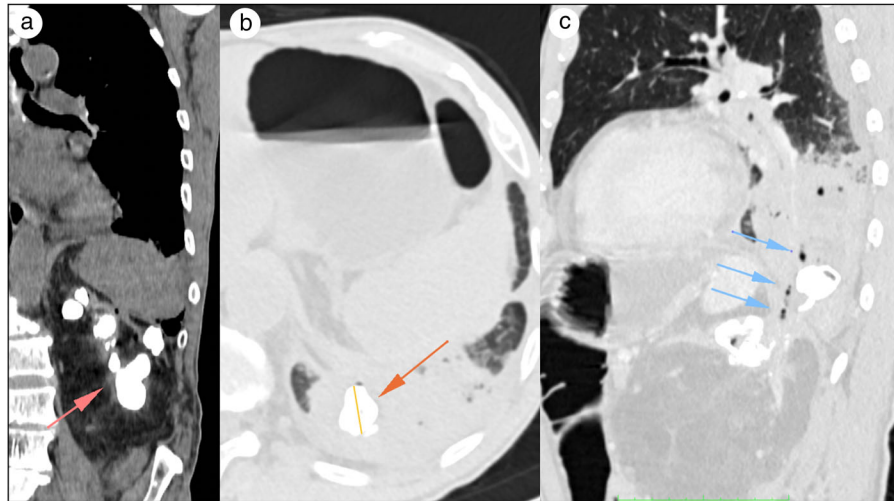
Noncontrast CT of the chest, abdomen, and pelvis showing (a) fragmented left-sided staghorn calculi; (b) calcification of 22 mm within the left lower lobe; and (c) bronchorenal fistula.
